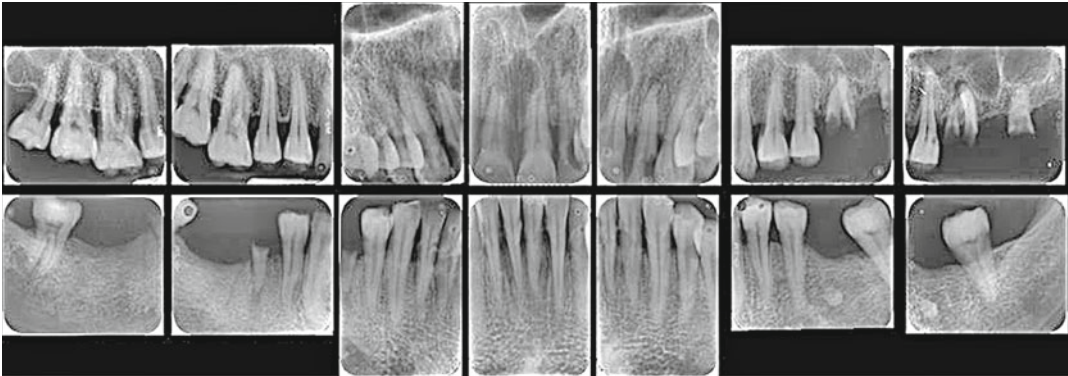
Full mouth radiographic profile
